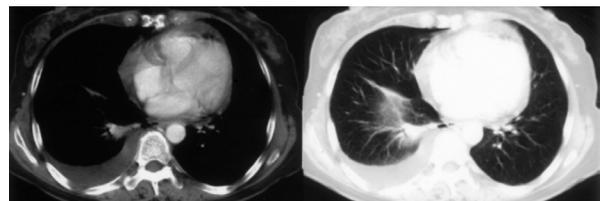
(A) Chest CT at diagnosis showed a heterogeneous consolidative tumor mass in the right lower lobe of the lung, with pleural metastases, pleural effusion, and bilateral lung metastases. (B) Chest CT showed tumor regression after gefitinib treatment for 3 months.
